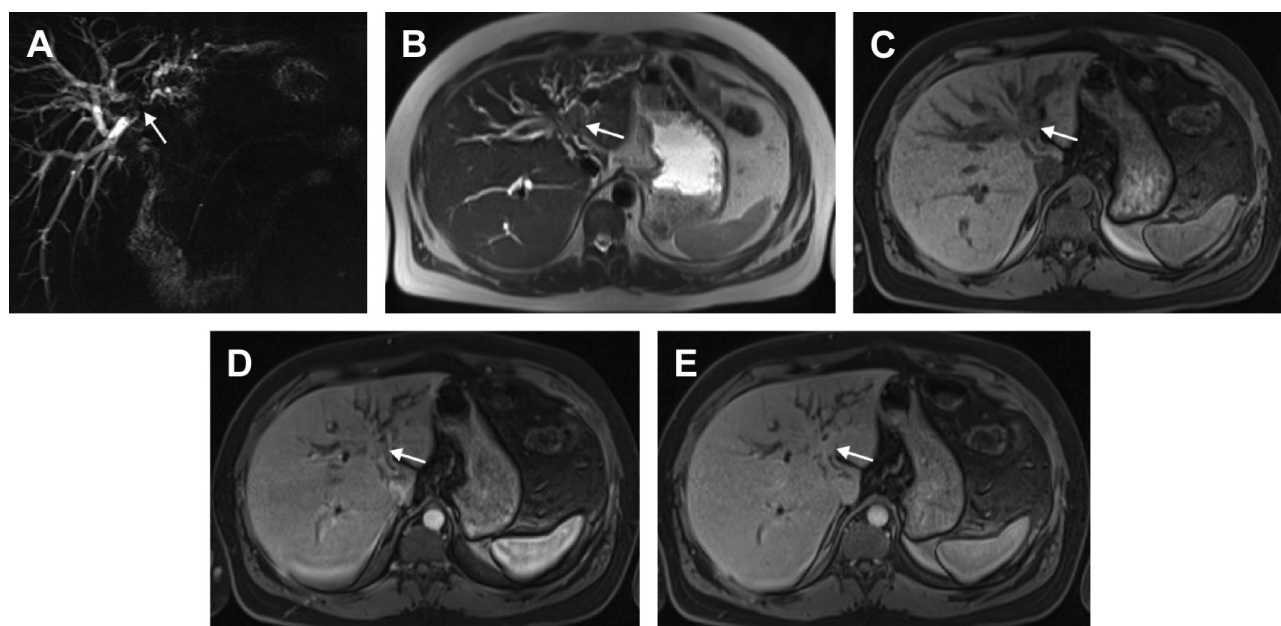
A 32-year-old man with jaundice. (A) Coronal slab MRCP demonstrates marked intrahepatic bile duct dilatation with obstruction at the biliary confluence (*arrow*). (B) Axial single-shot T2W image shows infiltrative soft tissue at the site of obstruction at the hilum (*arrow*), growing preferentially along the left portal tracks. Axial precontrast (C), arterial (D), and delayed (E) phase postcontrast images shows progressive enhancement of this soft tissue (*arrow*) in keeping with a superficial spreading cholangiocarcinoma. This patient underwent multiple ERCPs with brushings, all negative for tumor. A second opinion at an outside medical center yielded additional ERCPs and a laparoscopic lymph node biopsy, all again negative for carcinoma. The patient returned to our center and underwent extended left hepatectomy, which confirmed the diagnosis of superficial spreading cholangiocarcinoma as depicted on the initial MR imaging.
